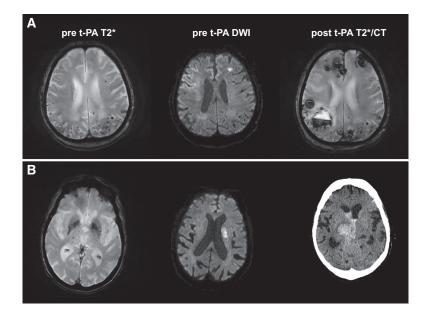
Imaging of 2 patients with multiple cerebral microbleeds (CMBs) who developed intracerebral hemorrhage after thrombolysis. A. An 84-year-old man with dysarthria, left-sided hemiparesis, and hemineglect (Age-Related White Matter Changes [ARWMC] score, 10). Left, Multiple CMBs in predominantly lobar distribution on pretreatment MRI. Middle, Diffusion-weighted imaging (DWI) shows diffusion restriction in the territory of right middle cerebral artery (MCA, frontotemporal) and left MCA (frontal). Right, Multiple parenchymal hemorrhages on post-thrombolysis MRI. B, An 89-year-old woman with sudden dysarthria and right-sided hemiparesis (ARWMC score, 15). Left, Multiple CMBs in predominantly deep localization on pretreatment MRI. Middle, Diffusion restriction in the left MCA territory on DWI. Right, Parenchymal hemorrhage on post-thrombolysis computed tomography (CT). t-PA indicates tissue-type plasminogen activator.
